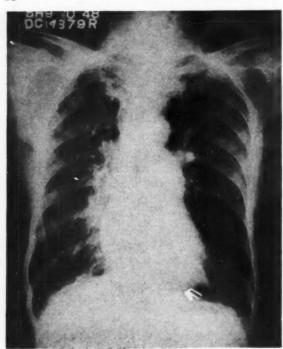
Case iv. X-ray of the chest.
